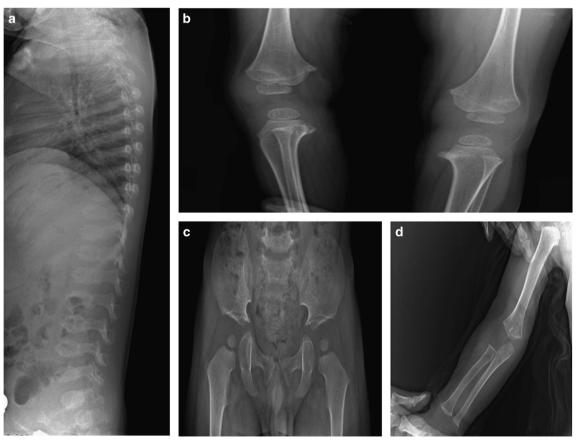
Radiographic findings in the PSACH proband. (a) Radiograph showing anterior beaking of the vertebral bodies. (b) Radiograph of knees. (c) Radiograph showing small femoral heads, flared metaphyseal borders and widened symphysis pubis. (d) Radiograph of ulna and radius. PSACH, pseudoachondroplasia.
